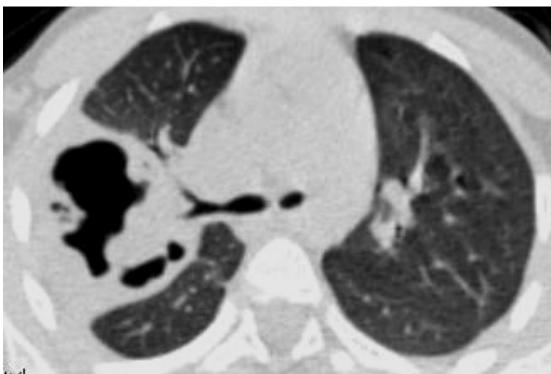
Axial CT, lung window at the level of bronchus intermedius bifurcation shows ill-defined irregular thick walled cavitary lesion at right lung involving the posterior part of middle lobe and anterior part of lower lobe proved to be necrotizing pneumonia.
